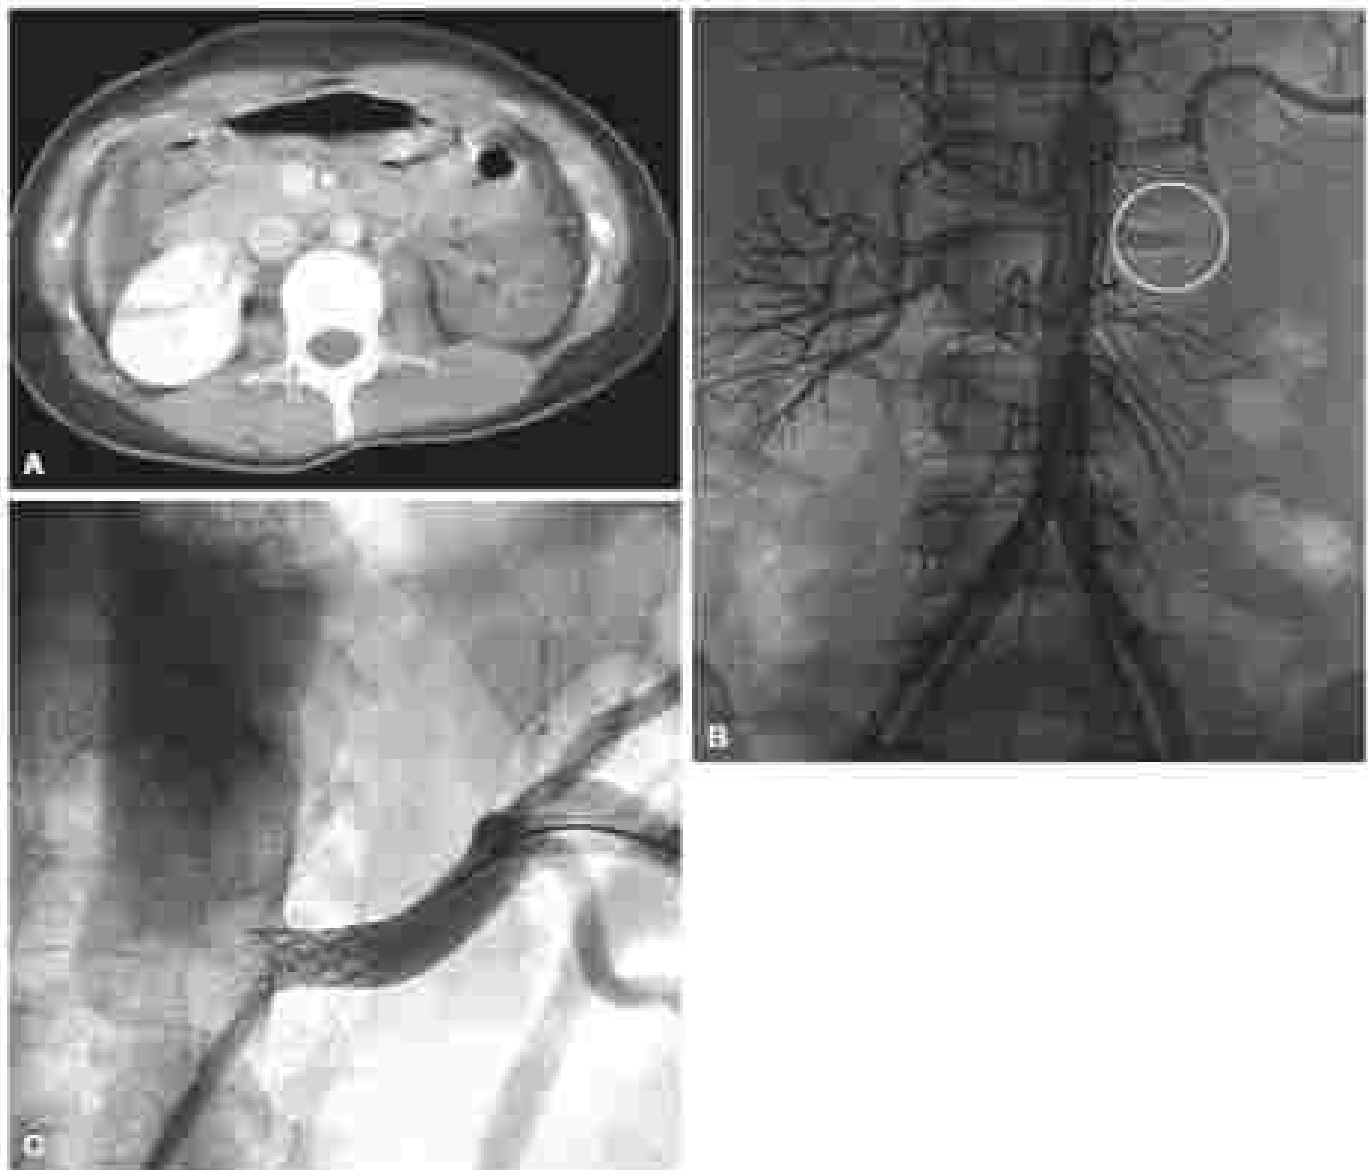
Blunt injury to the left renal artery. (A) Computed tomography scan showing a nonfunctioning left kidney after a traffic injury. (B) Angiography shows complete occlusion of the renal artery (white circle). (C) Retrograde aortogram with an endovascular stent (arrow) after AA (type III) aortic arch aneurysm surgery and retrograde therapy. *Acta Orthopædica Fennica*, 2011, 2.
